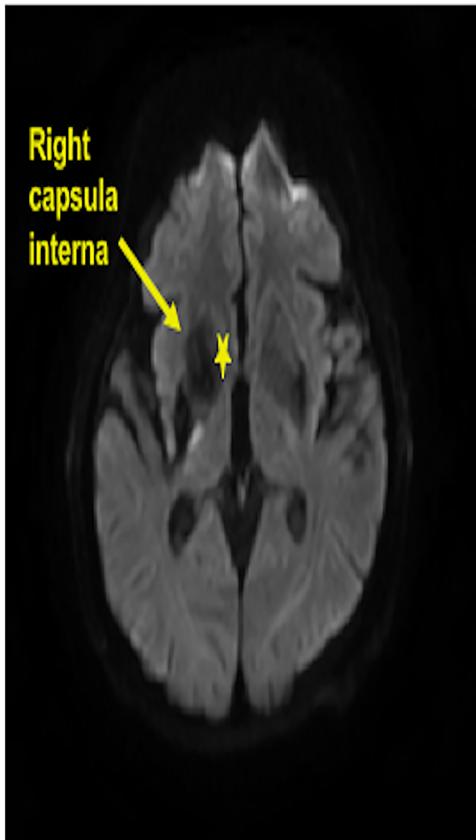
Diffusion magnetic resonance imaging showed an acute ischemic infarction at the right capsula interna.
